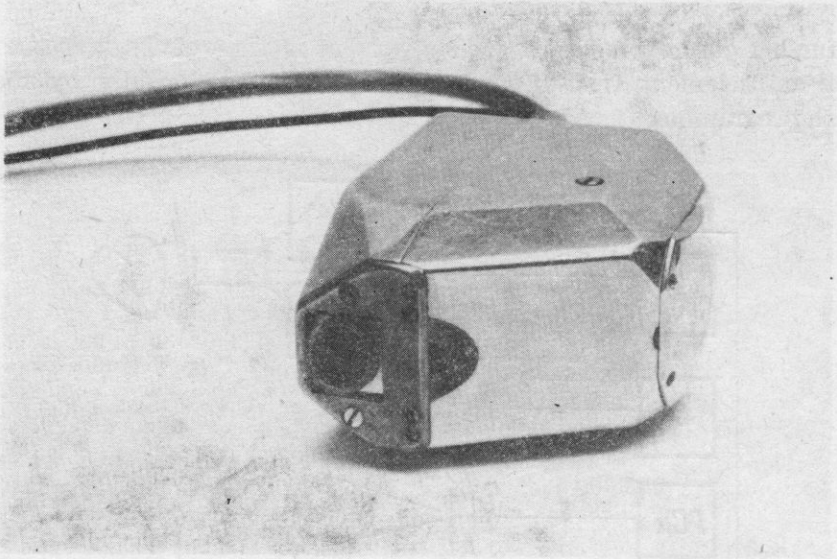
Ultrasonic scanner (overall dimensions  $100 \times 75 \times 50$  mm) with a mechanically oscillating piezoelectric transducer (see Fig. 1, II)
